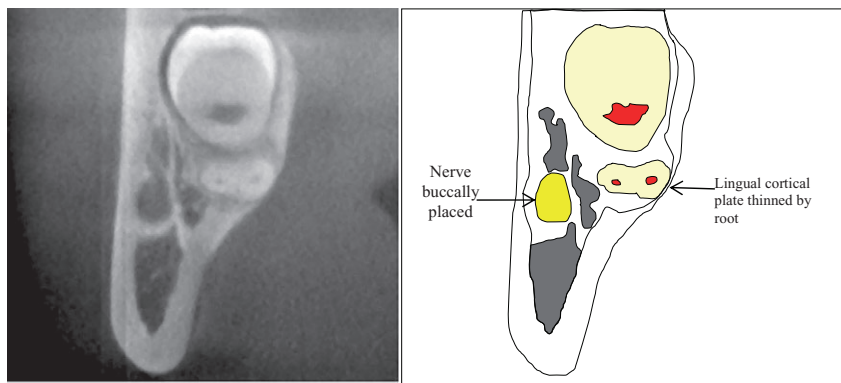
Coronal CBCT of Figure 7 demonstrating loss of lingual cortical plate by tooth substance only. Note buccal position of nerve.
